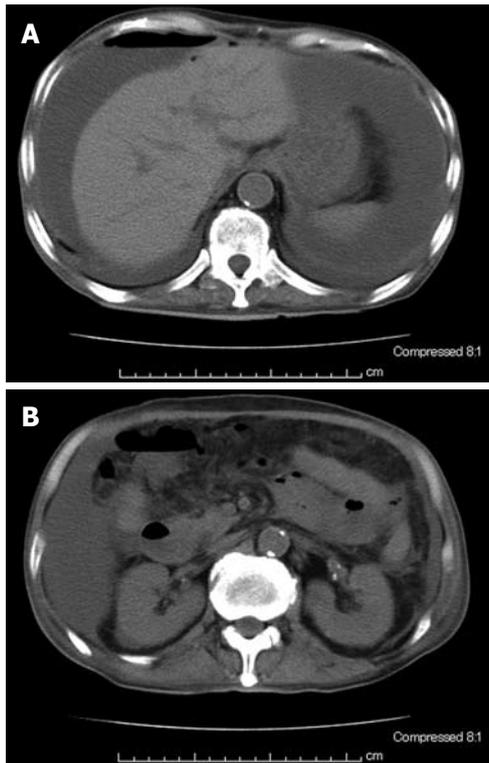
Abdominal computed tomography. A: Free-air, ascites; B: Swelling of the ileal loop.
